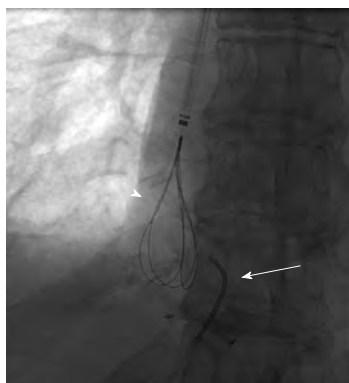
Fluoroscopic image demonstrating a loop snare inserted through the internal jugular vein access (arrowhead), and an angled catheter (arrow) through the right hepatic vein. Access to the right hepatic vein was achieved *via* percutaneous ultrasound guided puncture.
